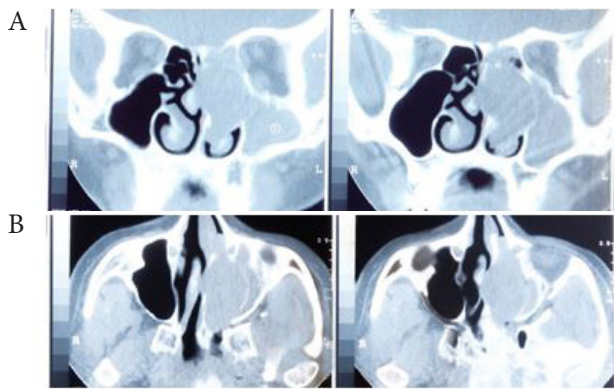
CT images (without contrast) (A) coronal and (B) axial views of the nose and sinuses demonstrate a left nasal soft tissue lesion. Lateral displacement of medial antral wall is due to the thinning of adjacent bones caused by pressure remodeling. Opacification of the left maxillary sinus is due to the obstruction by the mass.
